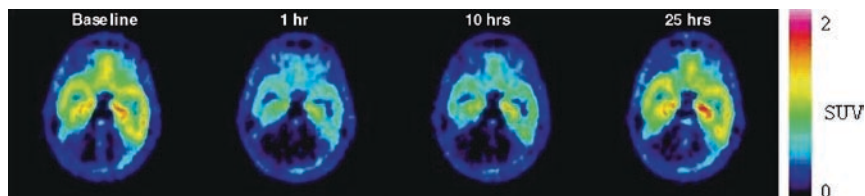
[^{11}C]-WAY-100635 uptake in human temporal cortex. The scans were taken before and at different times (hours) after administration of 5 mg of lecozotan IR formulation to a young healthy subject. $5\text{HT}_{1\text{A}}$ receptor occupancy of lecozotan, calculated based on uptake, serves as a biomarker of target-compound interaction, thus demonstrating CNS target engagement. SUV standardized uptake value. Figure courtesy of Dr. Sageeta Rajee, Wyeth Research, Collegeville, PA
